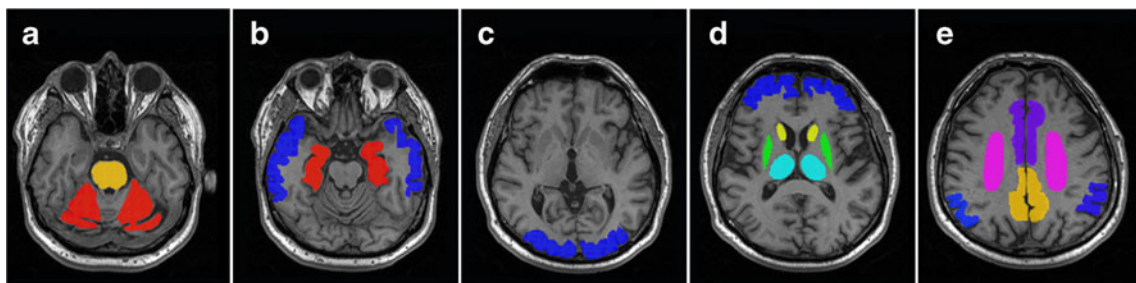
Representative individual 3-D T1-weighted MRI data set with display of the conventional (manually defined) volume of interest (VOI) set. Five paradigmatic transversal slices reoriented perpendicular to the anterior commissure-posterior commissure (AC-PC) line. VOIs were defined for a cerebellar cortex (red) and pons/midbrain (yellow), b
